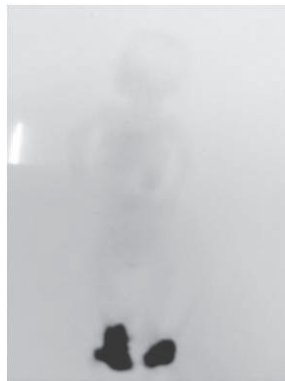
Lymphoscintigraphy showing lack of tracer migration in lower limbs
